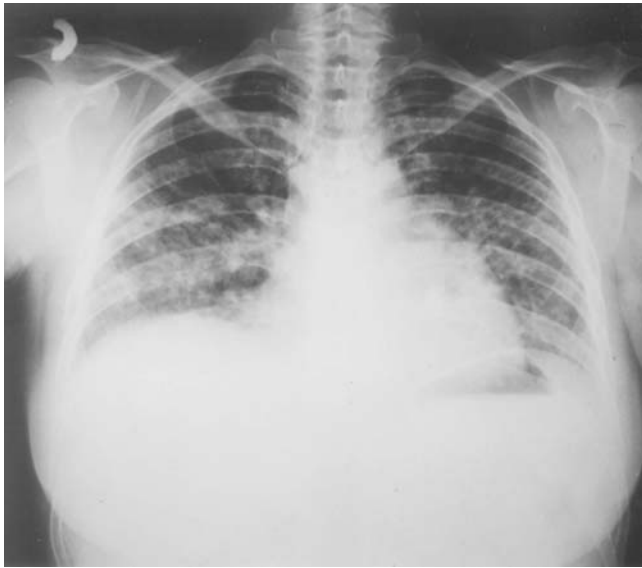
Chest X-ray representing the Ro stage II of lung sarcoidosis. At that time (1995), the patient had no history of abdominal symptoms and responded to corticosteroid therapy.
